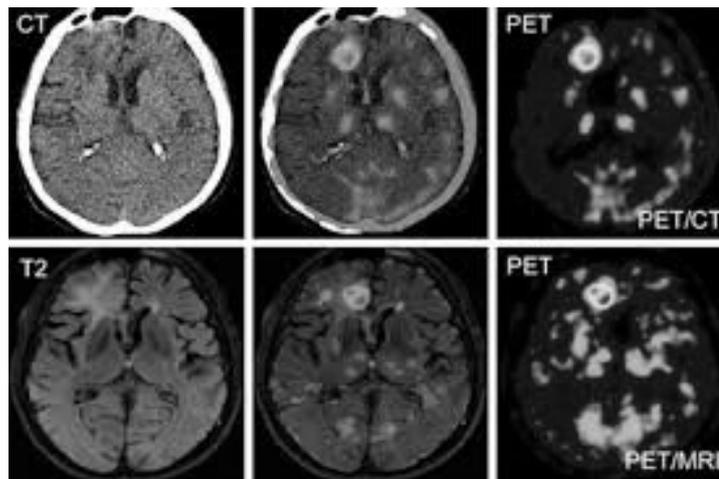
Fusion of PET with CT & MRI [160]
